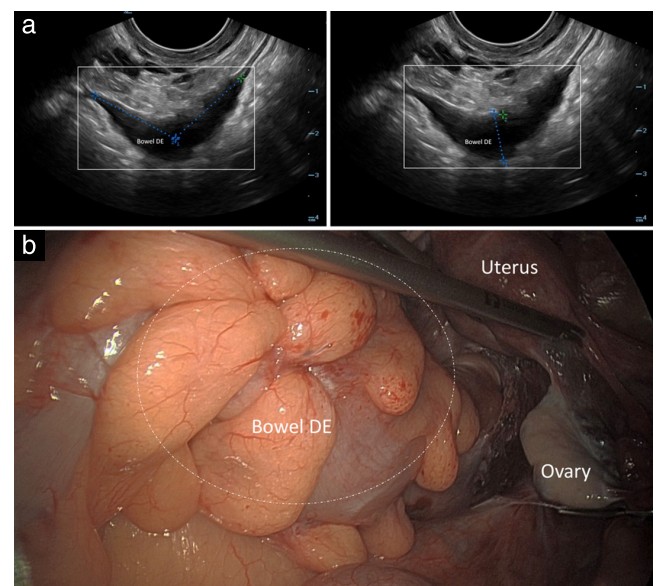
Diagnosis of deep endometriosis (DE) in the bowel on transvaginal ultrasound (a) and corresponding laparoscopic image (b). Note that the bowel exterior appears atypical, and the size and depth of the underlying endometriosis cannot be appreciated at surgery.
